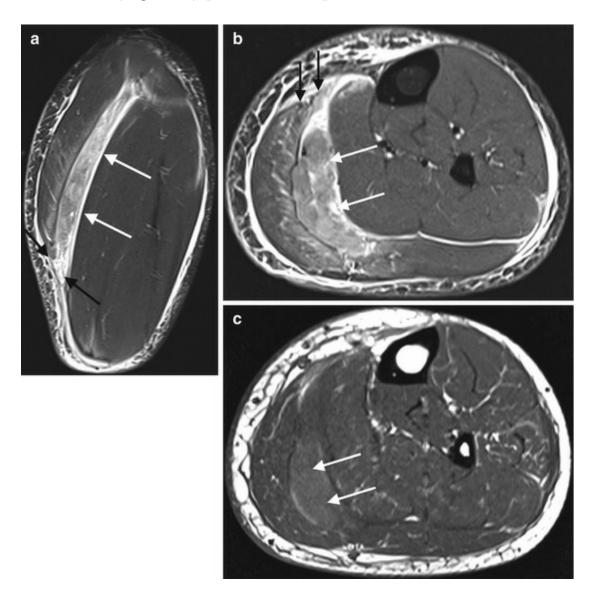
A 42-year-old male athlete with subacute left calf pain. Sagittal (a) and axial (b) fat-suppressed T2- and axial T1-weighted (c) MRI reveal left acute plantaris muscle injury (grade 2, black arrows) with aponeurotic hematoma (white arrows)
